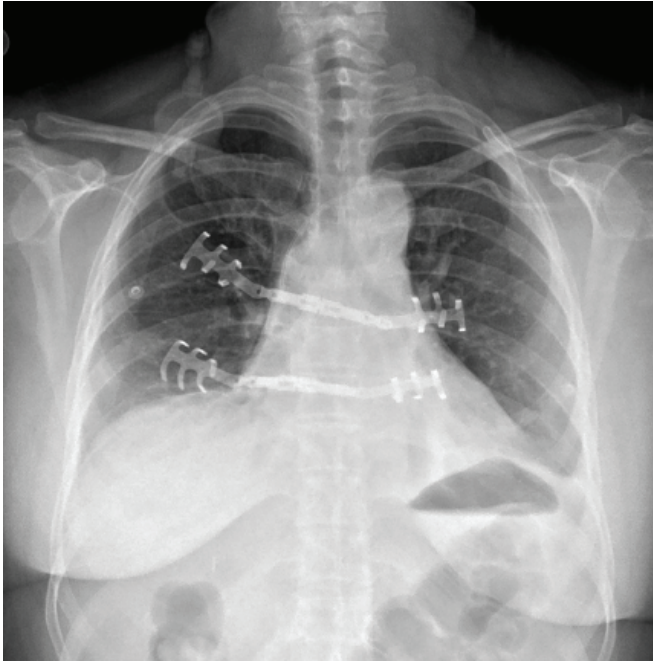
Postoperative chest radiography demonstrated the titanium bars in proper position.
